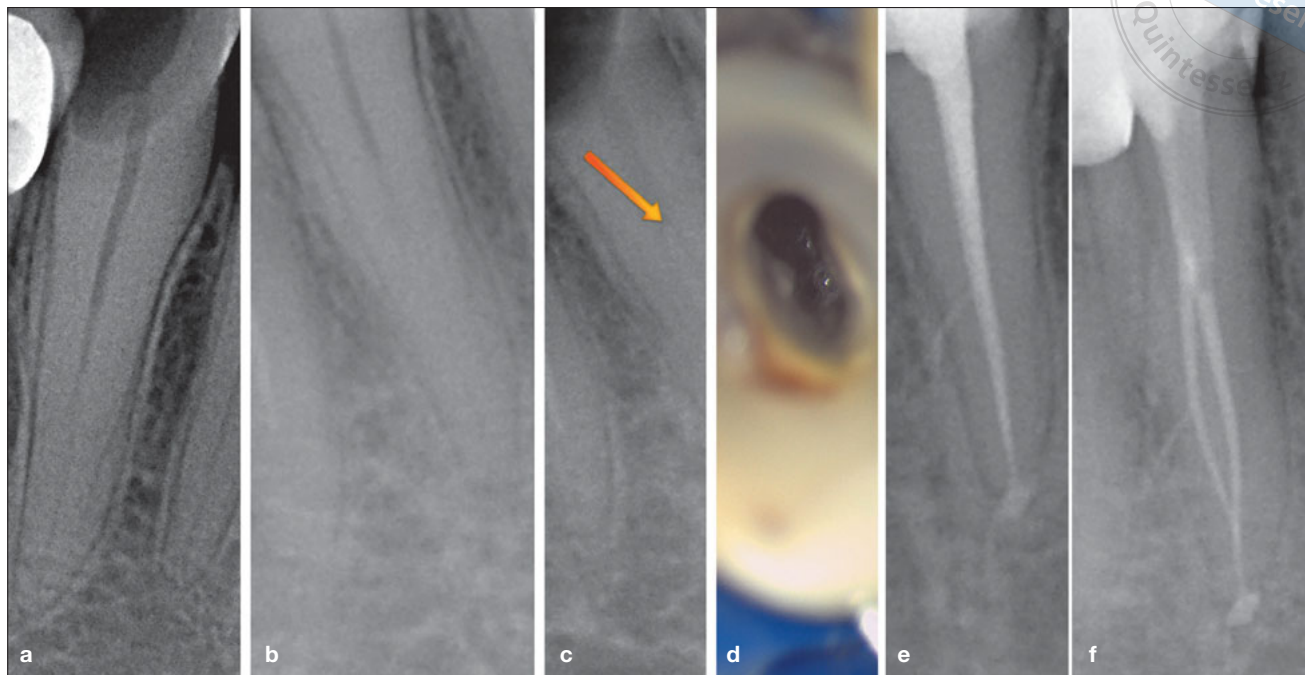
(a) Preoperative orthoradial radiograph showing one root and one canal. (b) Angulated radiograph showing the disappearance of the root canal pulp space, indicating a bifurcation. (c) Arrow highlighting the point of bifurcation. (d) Intraoperative photograph of the pulp chamber. (e) Postoperative orthoradial radiograph. (f) Postoperative angulated radiograph.
